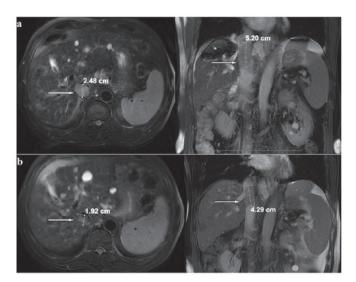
A partial response was achieved in a 61-year-old male with advanced HCC 4 months after receiving a combination of sorafenib and local therapy [transarterial chemoembolization (TACE) and cryoablation]. (a) MR image showing vena cava tumor thrombus prior to sorafenib treatment (maximal diameter, 2.48 cm; maximal length, 5.20 cm). By TACE and cryoablation, two tumor nodules in the liver exhibited coagulation necrosis and the patient began to receive sorafenib. (b) Follow-up MR images obtained 4 months after receiving a combination of sorafenib and local therapy showing the decrease of the vena cava tumor thrombus (maximal diameter, 1.92 cm; maximal length, 4.29 cm). No tumor recurrence in the liver occurred. HCC, hepatocellular carcinoma; MR, magnetic resonance.
